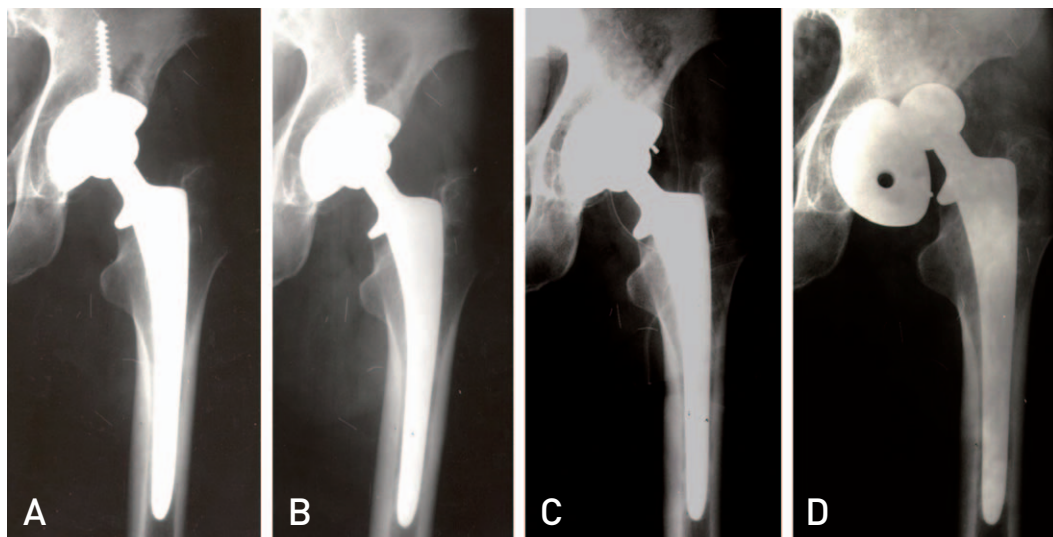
(A) Radiograph of a 36 year old patient at 4 years of follow-up. A focal acetabular osteolysis was seen in zone 1. (B) The osteolysis was progressive at 6 years of follow-up. (C) Curettage and allobone grafting was done for progressive acetabular osteolysis. The polyethylene liner was changed and screws were removed. (D) Radiograph shows that the acetabular cup has moved to a more vertical position at 4 months after the reoperation.
